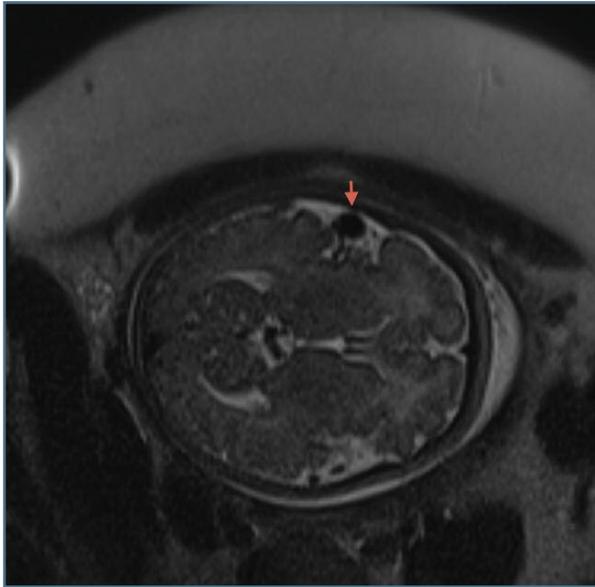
Fetal brain MRI, T2-HASTE weighted transverse and coronal images, showing vascular ectasia pericerebral (14x10x12mm), in the upper part of the left Sylvian fissure, accompanied by left middle cerebral artery with increased caliber and dilatation of the adjacent cortical veins (Trolard and Labbé), thus, pial AVF, with the contribution of branches from the left middle cerebral artery. The authors highlight the nonexistence of mass effect on the brain parenchyma, edema or ischemia of venous origin
